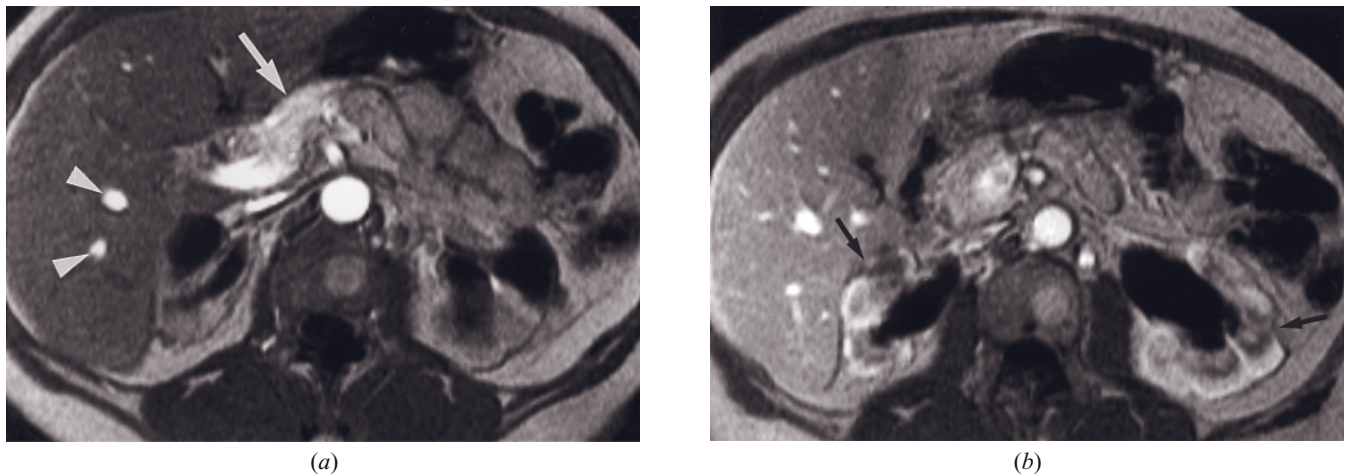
Complicated chronic renal obstruction. T1-weighted immediate (*a*) and 45-s (*b*) postgadolinium SGE images. Dilatation of both renal collecting systems has resulted from multiple urological procedures, including creation of an ileal conduit for obstruction of the distal ureters. Minimal cortical enhancement is shown on the immediate postgadolinium image (*a*). Image acquisition has been timed in the capillary phase of enhancement, as evidenced by high signal intensity of the body of the pancreas (arrow, *a*) and contrast in portal veins (arrowheads, *a*). Cortical enhancement has developed in a delayed fashion and is apparent at 45 s. The combination of obstruction associated with reflux has resulted in variation in calyceal dilatation and tissue pressure experienced by the different regions of the kidneys. The result is severe irregularity of the renal cortex (arrows, *b*). (Reproduced with permission from Kettritz U, Semelka RC, Brown ED, Sharp TJ, Lawing WL, Colindres RE: MR findings in diffuse renal parenchymal disease. *J Magn Reson Imaging* 1: 136-144, 1996.)
